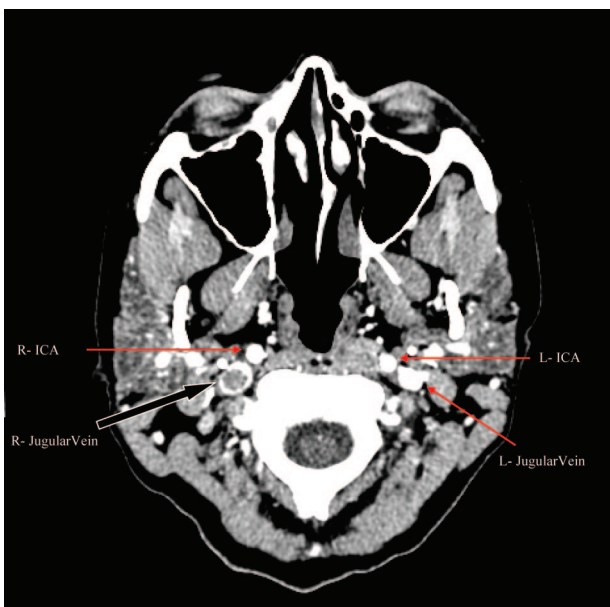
Computed tomographic venogram (axial) showing extension of the cerebral venous thrombosis down to the jugular vein (black arrow). R-ICA indicates right internal carotid artery; L-ICA, left internal carotid artery; R, right; and L, left.
